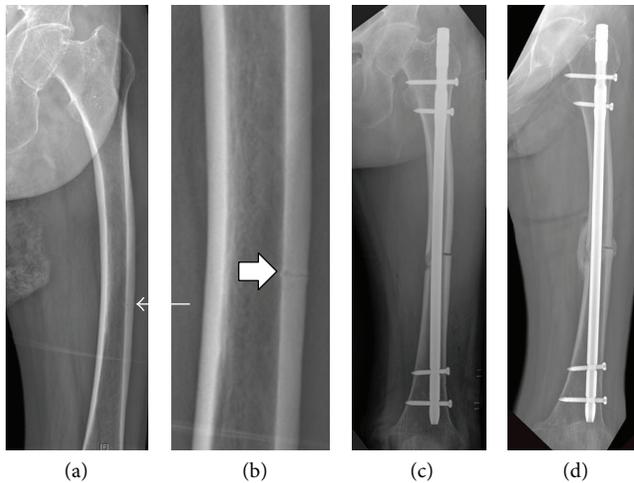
(a) A 74-year-old woman suffered thigh pain and her AP radiograph showed exaggerated femoral bowing with a transverse radiolucent line (arrow) in the lateral cortex of the distal 1/3 of the left femur. (b) A magnified view (box arrow) of the lesion revealed an incomplete, prefracture lesion of an atypical femoral fracture. (c) After preventive IM nailing, a complete fracture occurred. (d) The union was achieved with callus bridging at 18 weeks postoperatively.
